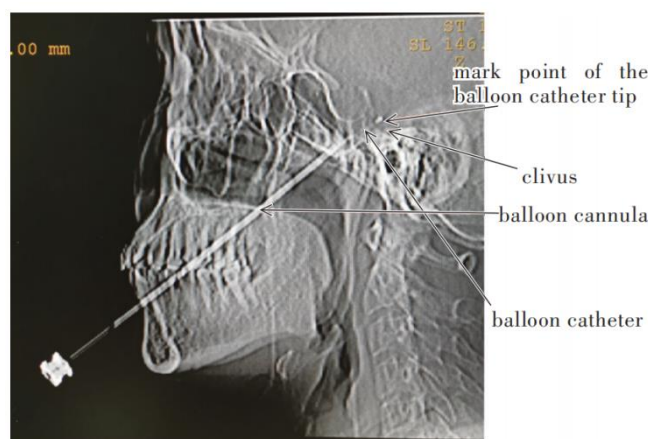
Lateral X-ray image during PBC puncture in a patient with trigeminal neuralgia.
